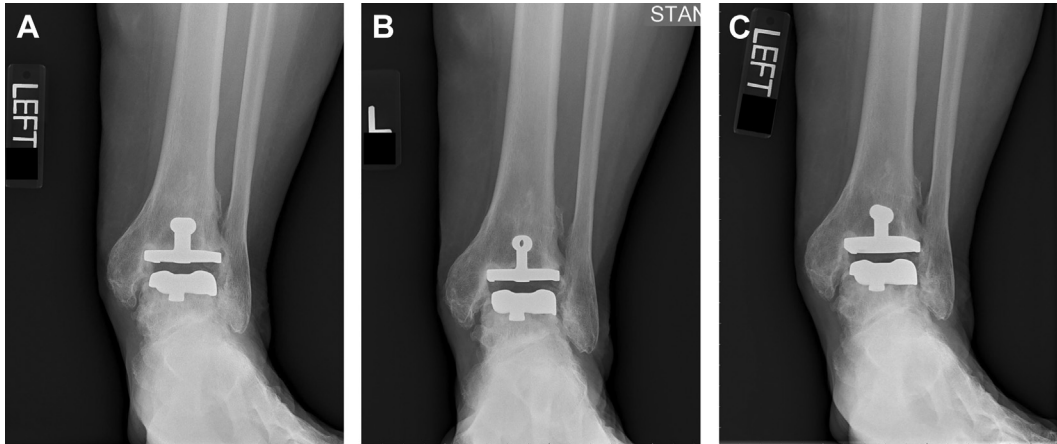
(A) Anteroposterior radiograph of the left ankle 7 years after TAA. Progressive cyst formation can be seen inferior to the lateral aspect of the talar component at (B) 8 years and (C) 9 years postoperatively. (Images courtesy of Dr. James W. Brodsky.)
